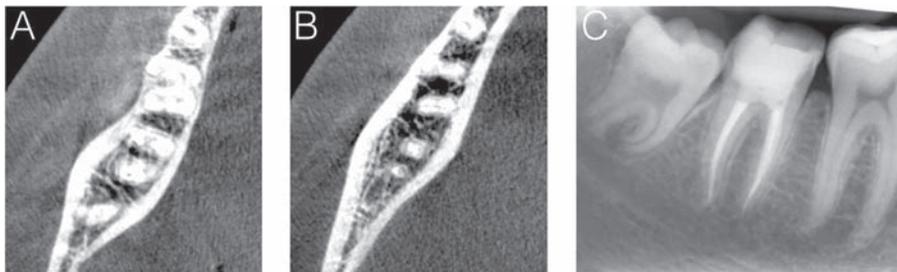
(A and B) Axial CBCT cross-sections showing good endodontic obturation and healing of the bone. (C) Periapical radiograph 3 years after the therapy showing absence of periapical lesions.
